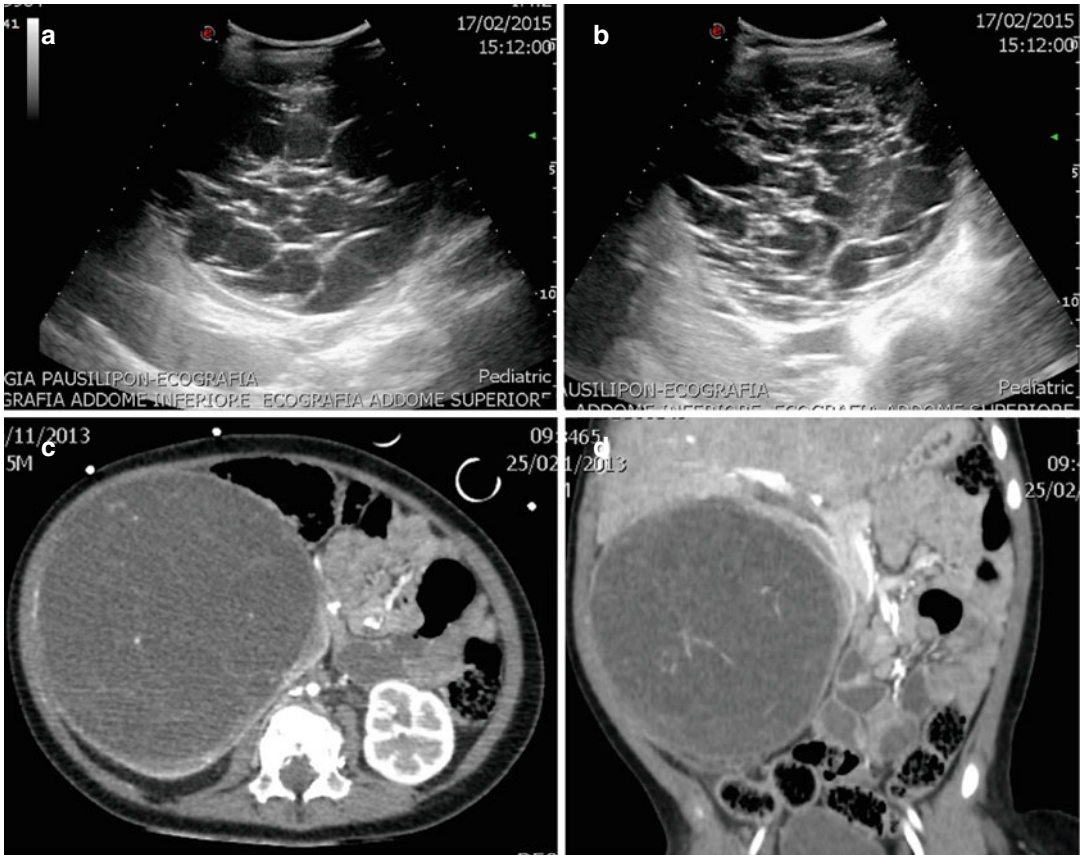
Male, 2 years old, arrives in emergency department with a palpable mass in the right abdomen. US images (a, b): a pluriconcamerate cystic mass with right renal origin is depicted. CT scans (c) and MPR coronal
